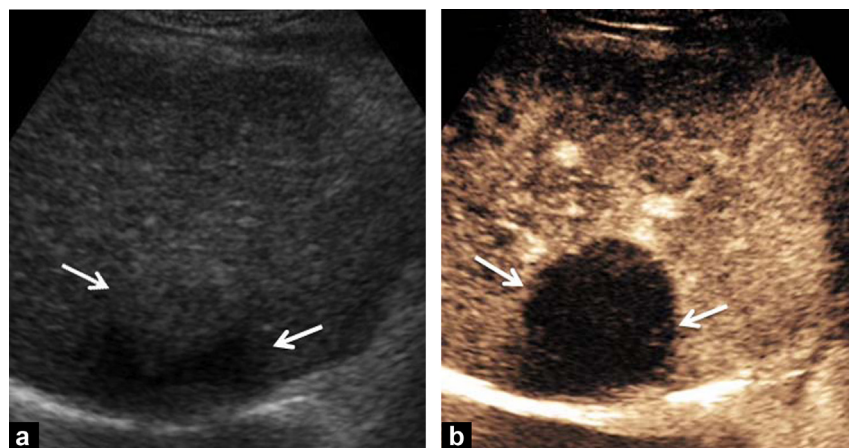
A 42-year-old man with hepatocellular carcinoma treated by transarterial chemoembolization (TACE). (a) Simultaneous display of B mode ultrasound and (b) arterial phase CEUS image shows a large, well-defined, heterogenous mass in segment VII of the liver (arrows in a). On CEUS image obtained at 28 s (arterial phase) following intravenous administration of SonoVue®, the mass does not contain any hyperenhancing area within or at the margin (arrows in b) suggesting complete response to TACE and no residual tumor or recurrence.
